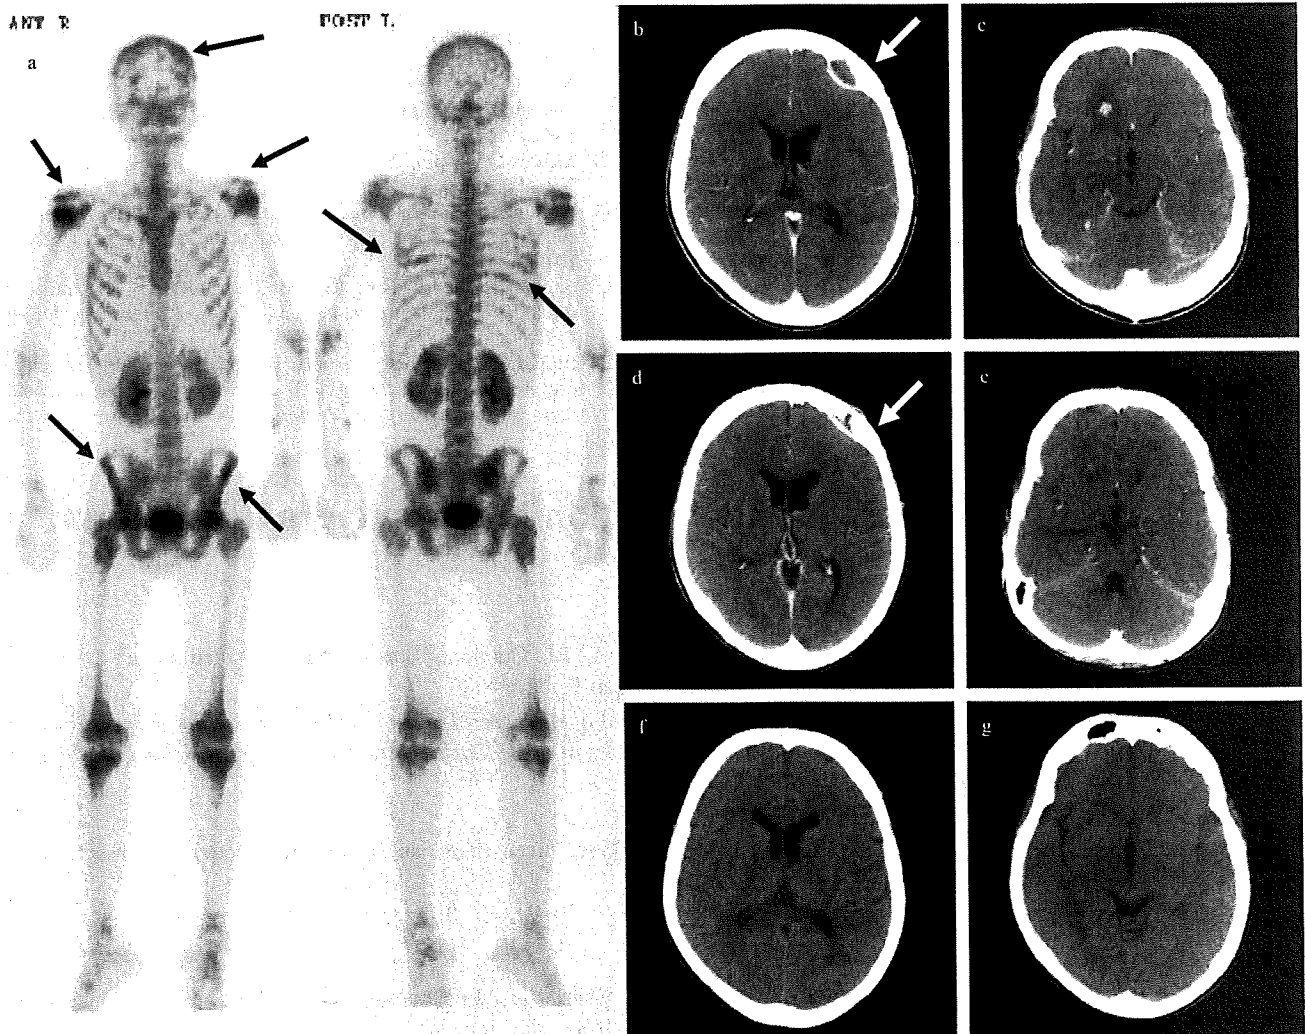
(a) ^{99m}Tc scintigraphy showing multiple osteomyelitis. (b,c) Computed tomography of the head before transplantation showed a subdural abscess with an osteolytic lesion, an abscess beside the right anterior horn of the lateral ventricle (arrows), and multiple brain abscesses. (d,e) Twenty-three days after transplantation, a subdural abscess (arrows) with an osteolytic lesion ruptured. (f,g) Forty-five days after transplantation, all the brain abscesses had disappeared.
